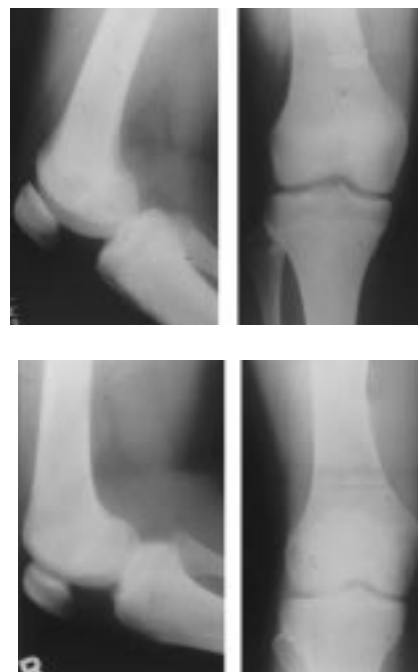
Radiographs of two skeletally mature girls, aged 10 years 11 months (top) and 13 years 7 months (bottom).
